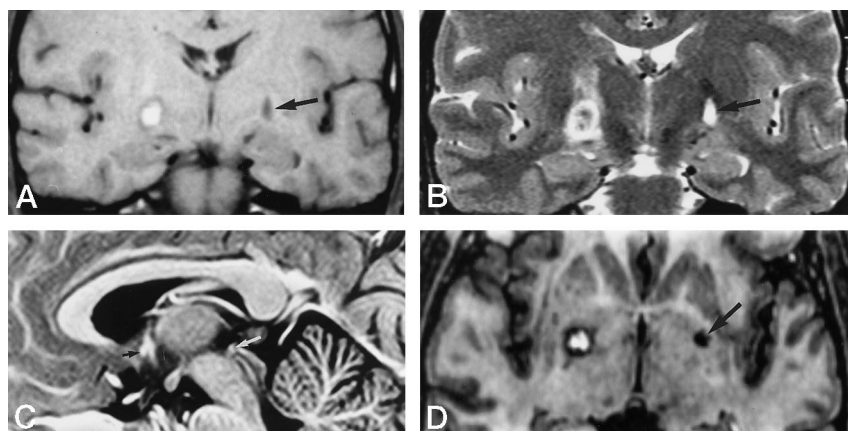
MR images 24 hours after right-sided pallidotomy. Note site of previous pallidotomy (on left) done 1 year earlier (arrow, A B, and D).
